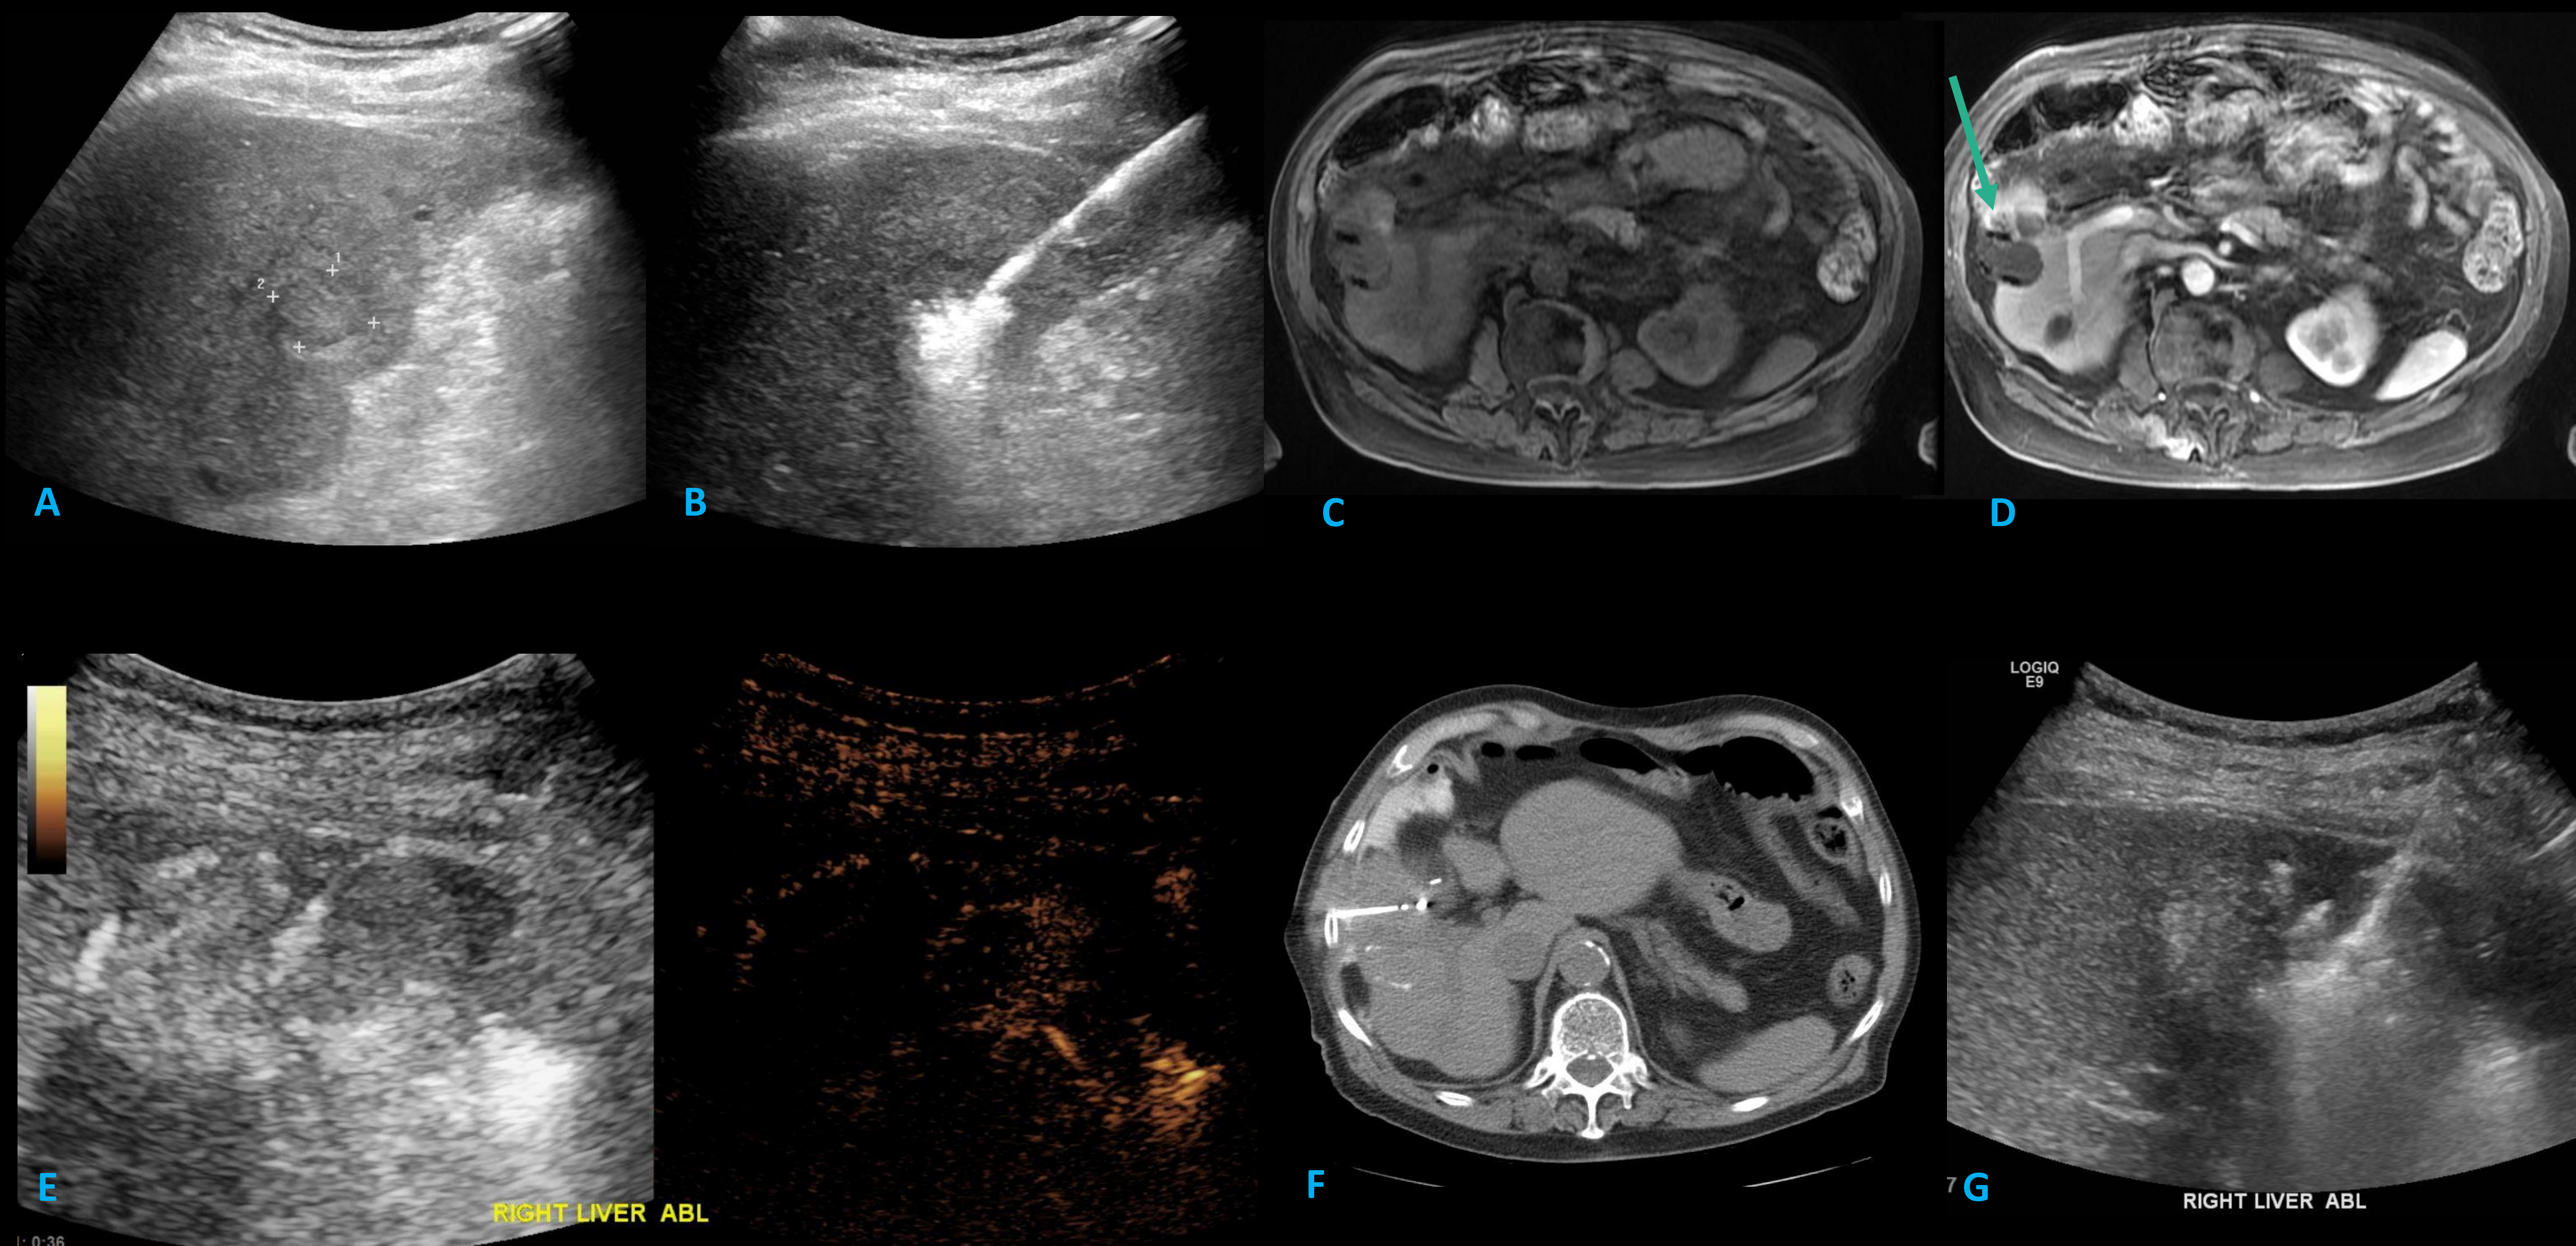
(A) Mostly isoechoic lesion in the right hemiliver. (B) Microwave ablation of the lesion. (C) Noncontrast and (D) postcontrast MR 3 months post-ablation shows small region of residual enhancement concerning for viable tumor (green arrow). (E) Contrast-enhanced ultrasound shows a peripheral rim of enhancement, greater on the left, compatible with residual tumor. Note adjacent bowel gas. (F) planning CT confirms ablation probe placement. Contrast was injected into the peritoneal cavity to "push" bowel away from the ablation zone. (G) Successful microwave ablation of the lesion.
